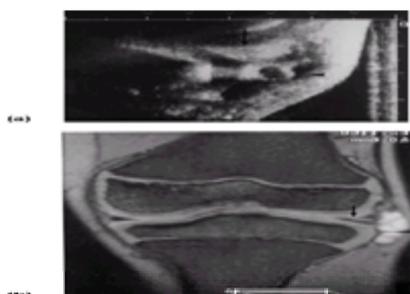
Meniscal cyst in an 8-year-old boy with knee pain and medial mass. (a) Ultrasonography shows a cystic mass (arrowhead) adjacent to the medial meniscus (arrow). (b) Frontal T_2 -weighted MR image shows a torn medial meniscus (arrow) and a meniscal cyst (arrowhead).
